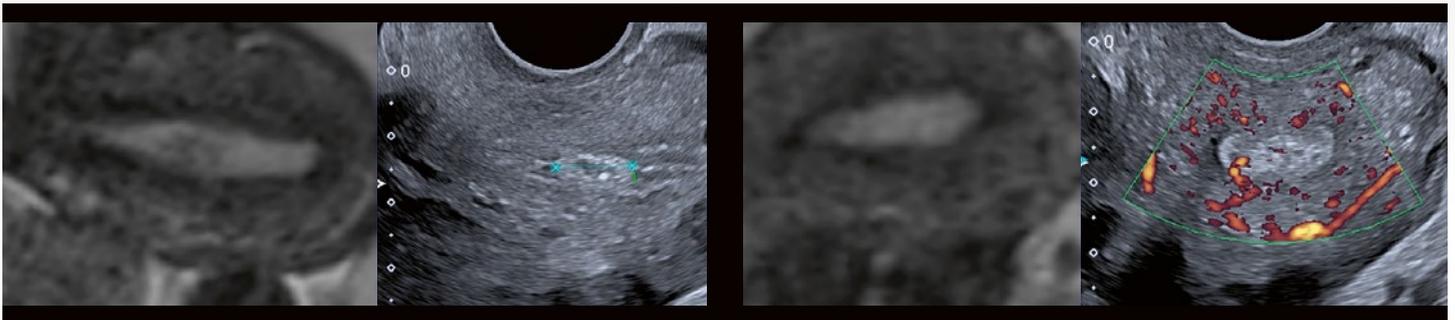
MRI/ultrasound sagittal and transverse sections: polyp with vascular pedicle.
